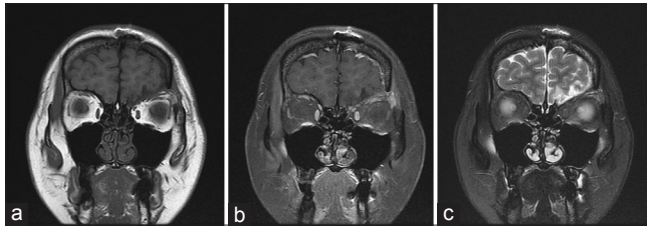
Post-operative orbit MRI. Coronal T1 weighted image (a), coronal T1 weighted image post gadolinium enhancement (b), coronal T2 weighted image (c) showing gross total removal of the tumor
